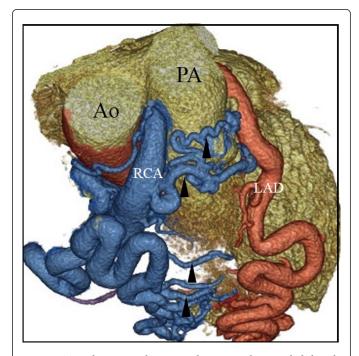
Tree-dimensional computed tomography revealed that the right coronary artery was originating from the pulmonary trunk. (): Collateral arteries between RCA and LCA.
